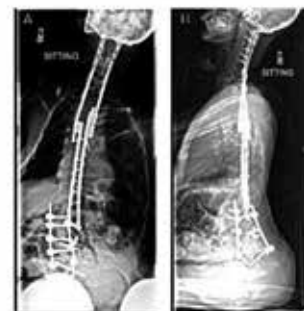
(Left A-B): (A) Anteroposterior and (B) lateral spine radiographs in a 43-year-old woman with myotonic muscular dystrophy type 1, 1.194 years after completion of O-P arthrodesis.
